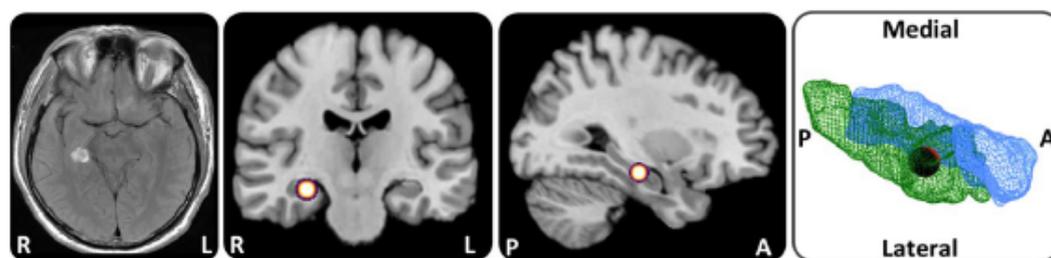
Lesion localization in a case of acute topographical disorientation. A T2 MRI sequence showed a focal hemorrhage in the right hippocampus and parahippocampus (left side). The lesion in full-scale (red sphere) was projected to a standard T1 brain template (middle) and a hippocampus (blue) and parahippocampus (green) 3D model (right side) to visualize the exact lesion localization. R: right, L: left, A: anterior, P: posterior
